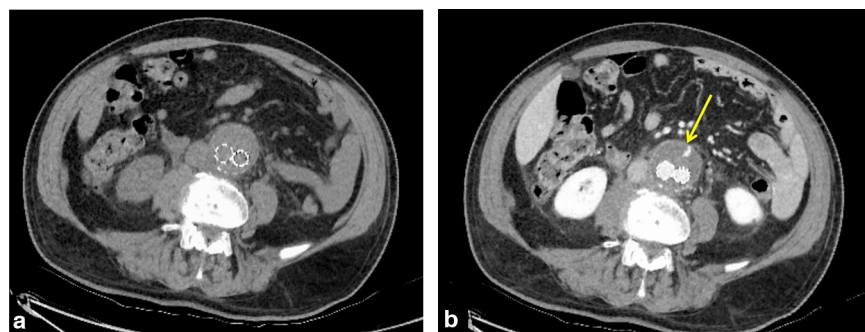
Follow-up computed tomography before and after contrast media injection: arterial phase, type-2 endoleak due to inferior mesenteric artery reinjection: a: axial slice before contrast media injection; b: same slice level after contrast media injection (arterial phase), type-2 endoleak (yellow arrow).
